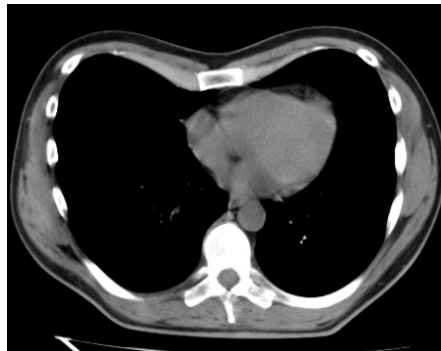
Example of axial chest CT images.
